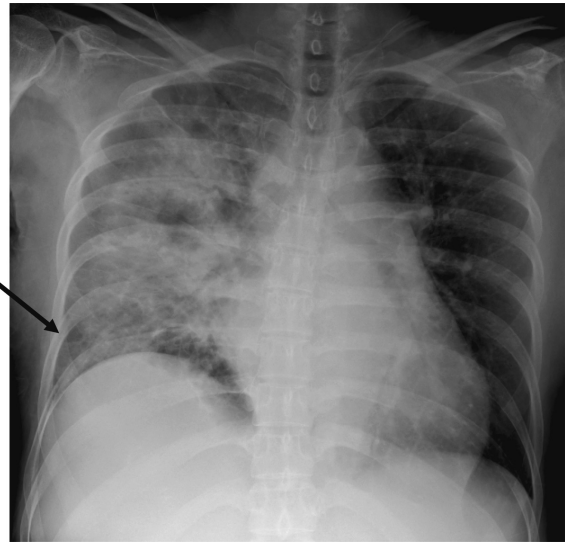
Imaging on arrival at our hospital (Chest radiography)
